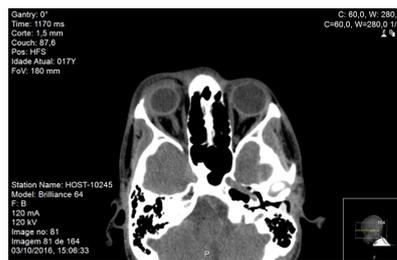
Orbital CT scan showing protrusion of the right orbit.
